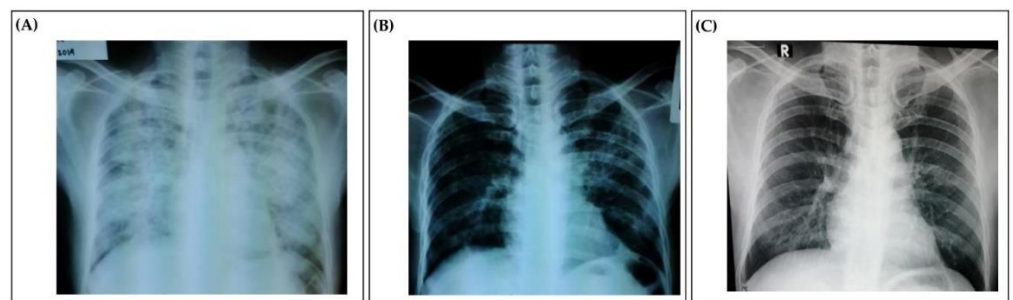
The patient's evolution was evaluated through radiological examinations. (A). Chest X-ray findings indicated PCP, pulmonary TB, and CAP. (B). Chest X-ray indicating pulmonary TB. (C). Chest X-ray revealing fibrosis adjacent to the right side of the heart.
